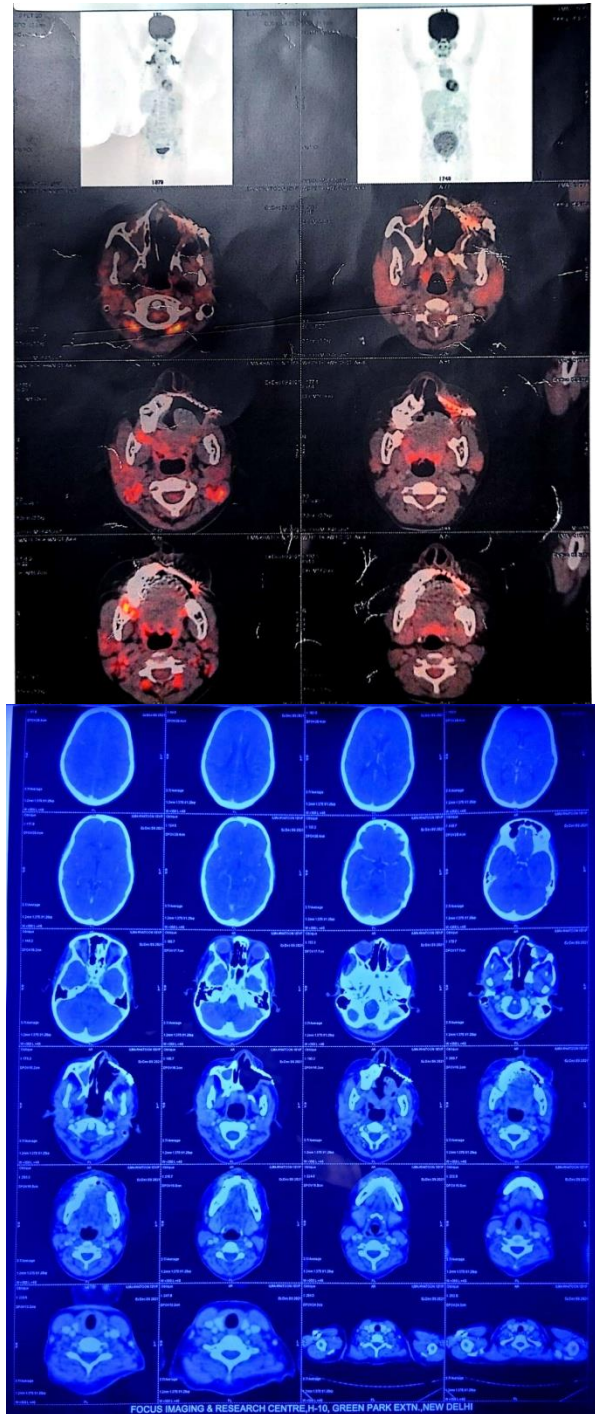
PET-CT Scan revealing recurrent disease on left side of face
